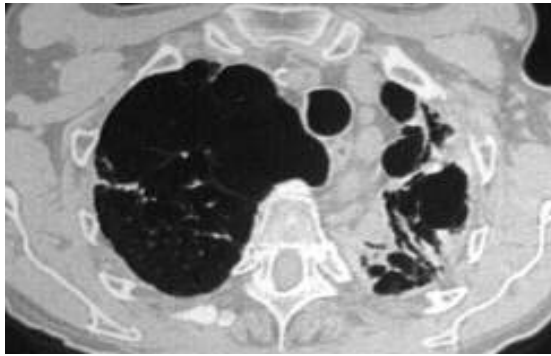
Axial CT, lung window at the level above the aortic arch shows bilateral segmental upper lobar fibrocavitary lesions more extensive on left side proved to be due to tuberculosis.
